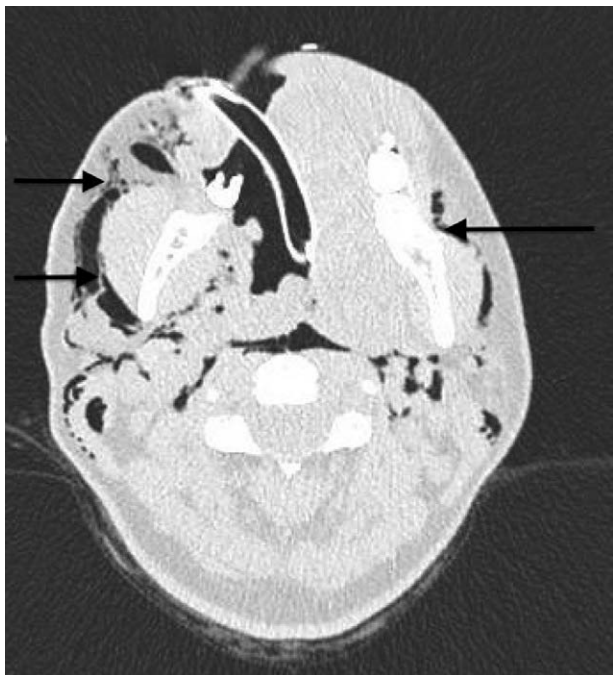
Computed tomography, transverse plane through cervical vertebra C1, showing extensive subcutaneous emphysema in the neck region and in the deep facial planes (around the right carotid and in the right parapharyngeal space).
